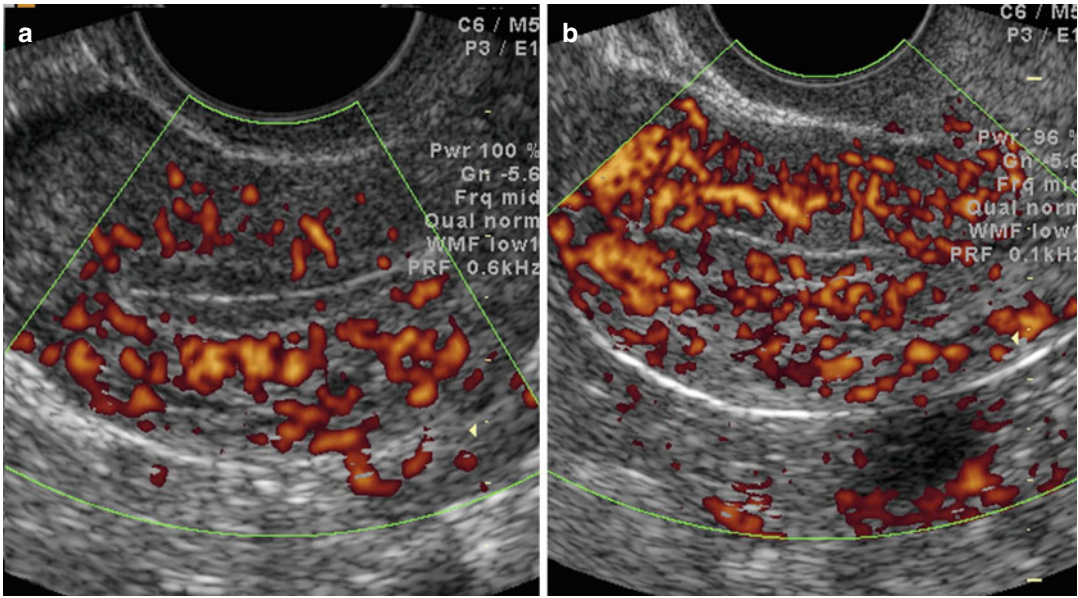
(a, b) Power Doppler showing well-vascularized endometrium
